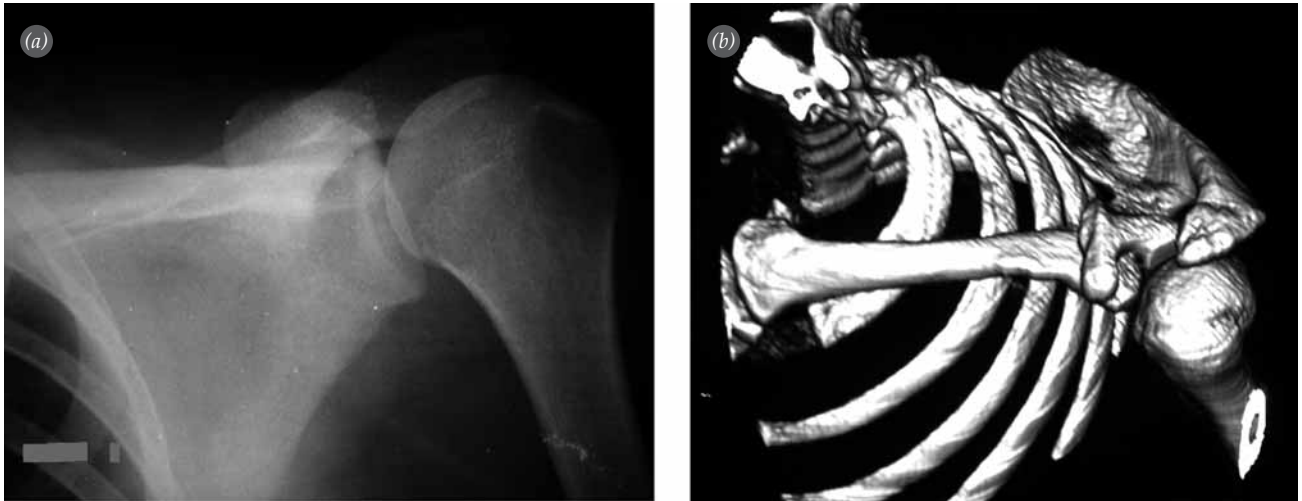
Preoperative (a) AP radiography and (b) 3D CT image.
